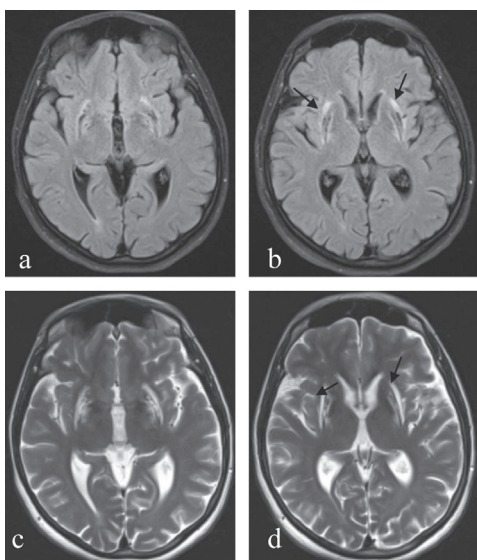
MRI of the brain in a young woman with Wilson disease. It is showing bilateral signal changes involving both lentiform nuclei on FLAIR (a and b) and T2 weighted images (c and d).
